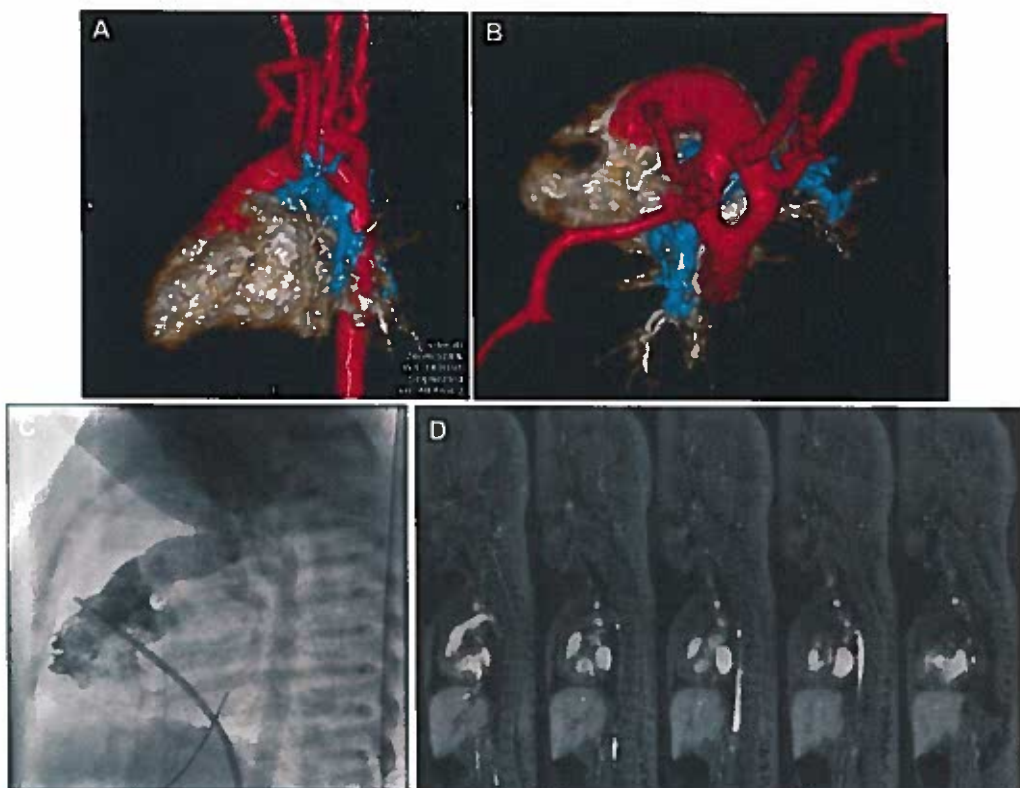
7-day-old boy (3.3 kg) with D-transposition of the great arteries (TGA) and unclear anatomy on echo. FE-MUSIC shows a double aortic arch (A, B) with severe compression of the trachea and esophagus. The patient underwent cardiac catheterization (C) for atrial septostomy prior to surgery, which confirmed the FE-MUSIC findings. Pulmonic valve and subvalvar pulmonic stenosis however, were not appreciated on cath, but confirmed intra-op. Tracheal compression was shown on MRI (D). CT angiography to further characterize tracheal rings was non-diagnostic because of a heart rate 160-170s bpm. All FE-MUSIC findings were confirmed during surgical division of aortic arch and Blalock-Taussig shunt creation.
